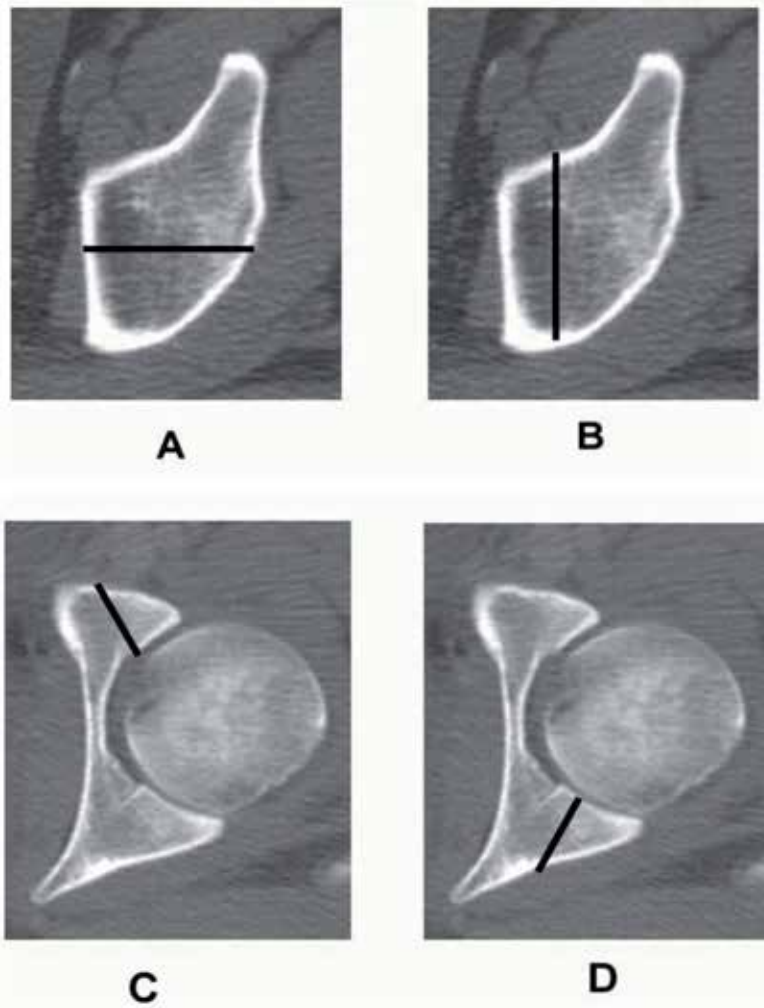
Orientation of fracture lines on two-dimensional computed tomography as they relate to fracture morphology. (A) Fracture of one or both columns. (B) Transverse fracture. (C) Anterior wall. (D) Posterior wall.
